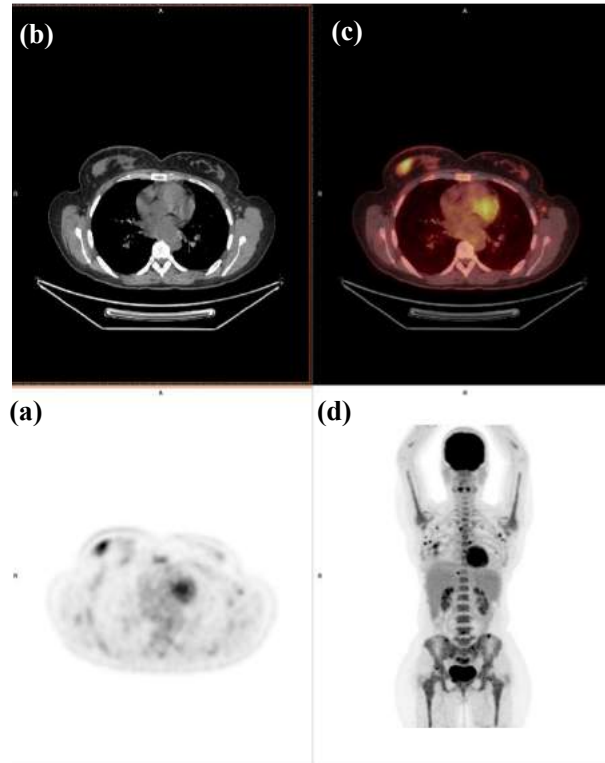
PET/CT images. A patient with tumor is observed in the right breast along with multiple metastases in the right axillary lymph nodes. Additionally, there are multiple metastases detected in the bones. (a) PET image, (b) CT transverse projection, (c) fused PET/CT and (d) Maximum intensity projection. Examination performed in PET/CT Unit, Nuclear Medicine Department, University Hospital in Cracow (Pracownia PET/CT Zakładu Medycyny Nuklearnej Nowego Szpitala Uniwersyteckiego in Kraków).
